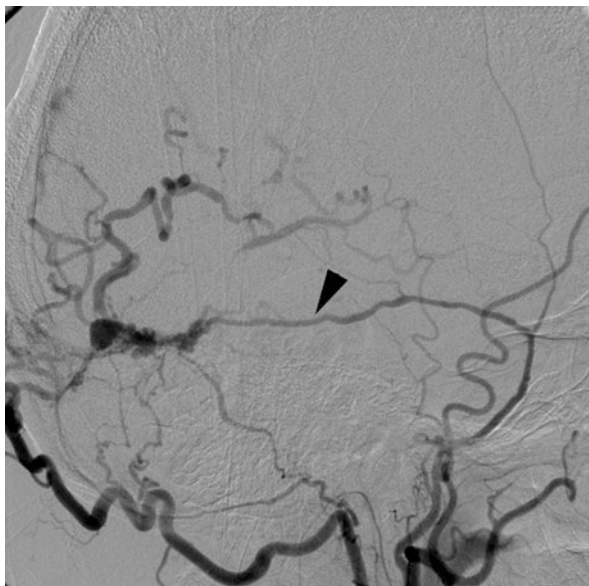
External to internal carotid artery collateral flow. Patient with a right cervical ICA dissection. CTA showed a right ICA dissection with severe lumen narrowing (a, arrow). MRI showed a large T1-hyperintense intramural hematoma (b, arrow). DSA showed ICA dissection (arrow) along with ECA to intracranial ICA collateral flow (c, arrowhead)
